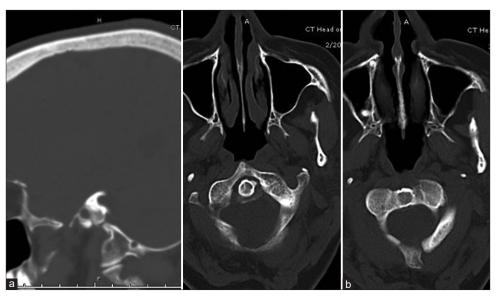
Computed tomography head without contrast (a) sagittal (b) and two axial views with evidence of occipitoatlantal assimilation
